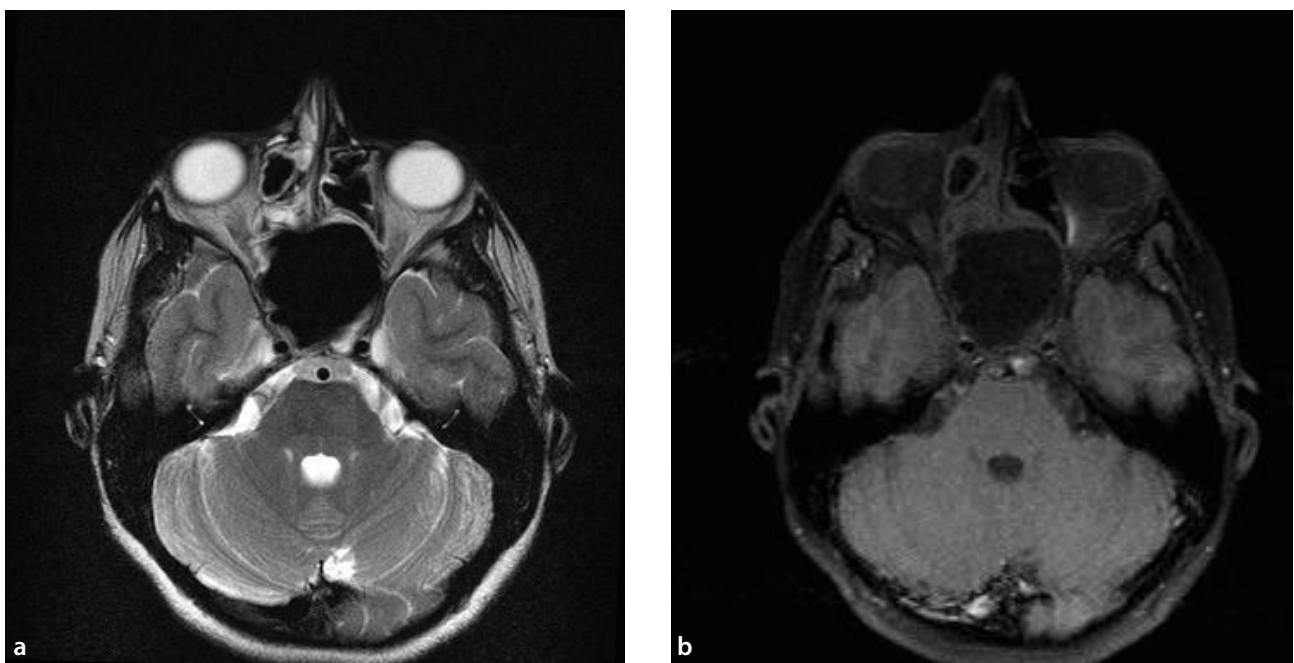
(a) Axial T2 and (b) axial FLAIR, showing homogeneous, diffuse hypointensity involving the expanded sphenoidal sinus.
